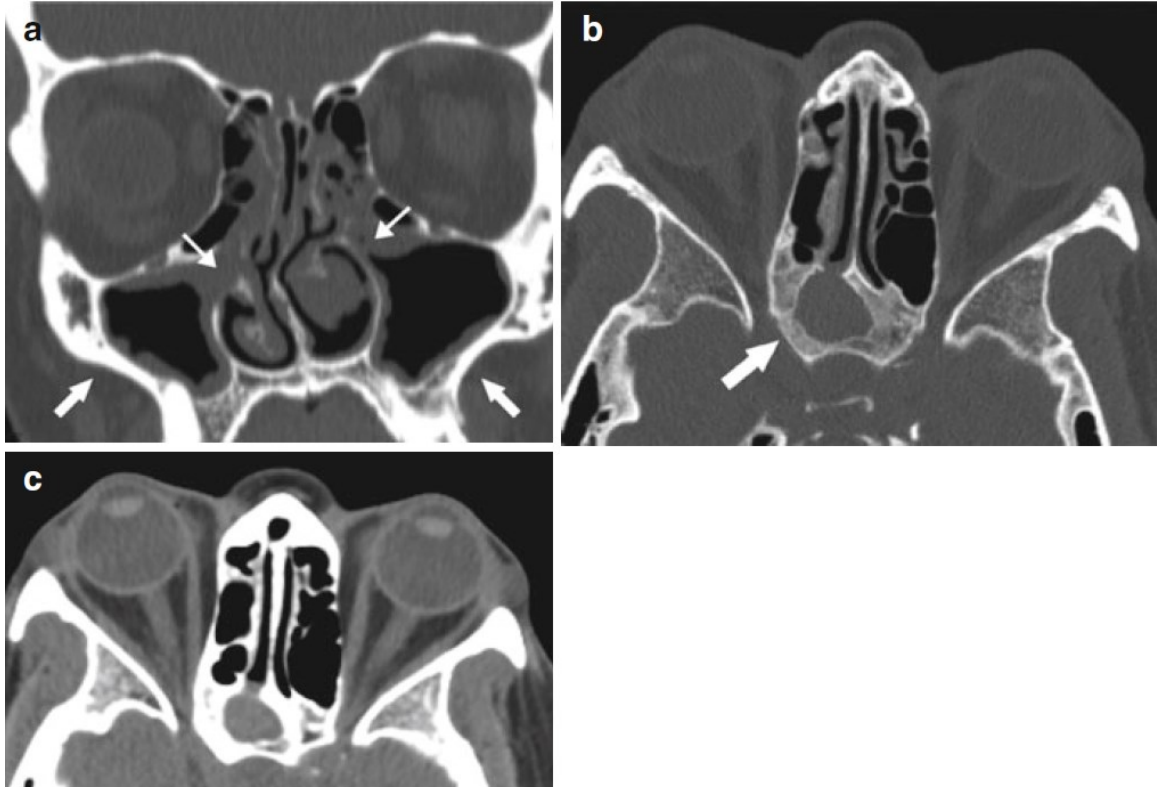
Varied appearance of chronic rhinosinusitis. (a) Coronal image showing bilateral maxillary sinus mucosal thickening, extending into the outflow tracts (*thin arrows*). Note the sclerosis and thickening of the surrounding maxillary sinus walls (*thick arrow*). Axial images in bone window (b) and soft tissue window (c), demonstrating chronic right sphenoid sinusitis, recurrent postoperatively, with opacification with high-density secretions extending through the sphenoid ostium and sclerosis and hyperostosis of the surrounding bone (*thick arrow*). Flanagan CE, Baugnon KL, DelGaudio JM. Radiographic Diagnosis of Chronic Rhinosinusitis. In: Batra PS, Han JK, eds. Practical Medical and Surgical Management of Chronic Rhinosinusitis. Cham: Springer International Publishing 2015:43-72.
